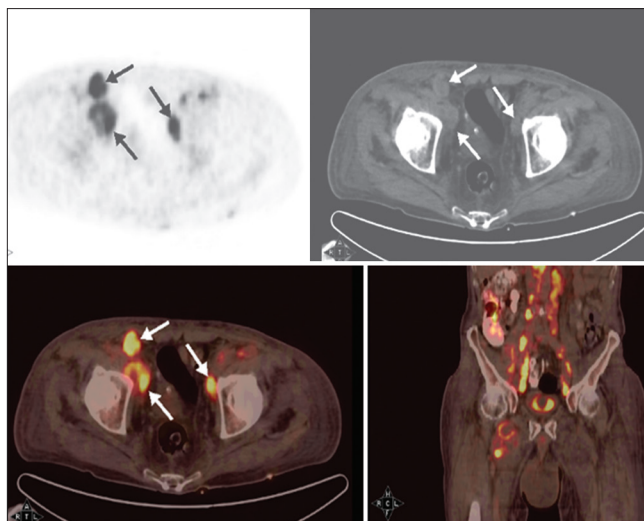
Pelvis axial PET, computed tomography, fusion and coronal fusion images showed multiple lymphadenomegalies in the iliac region
